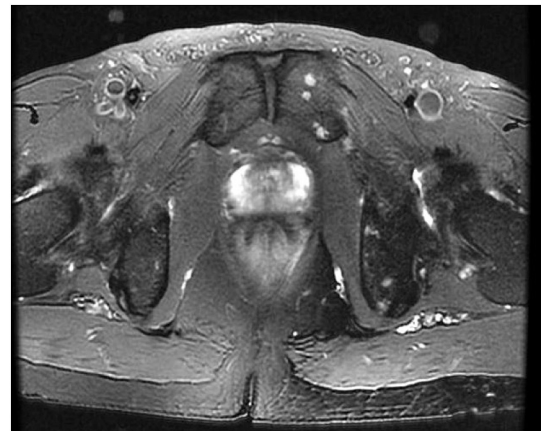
Prostate MRI showing abnormal signals in the bilateral and peripheral lobes of the prostate, suggesting a possibility of prostate cancer.
